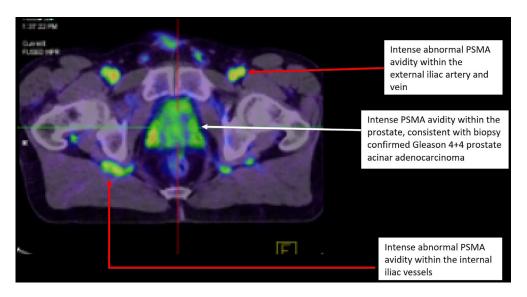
An axial section of AM's PSMA PET scan showing the prostate, which has intense PSMA avidity as expected, given his known biopsy confirmed Gleason 4+4 prostate cancer. There is also radionuclide distribution in his vasculature – bilateral femoral arteries, veins, iliac veins and arteries and their branches.
